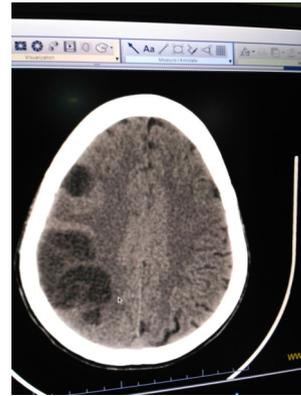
CT image showing infarct Analysis of the data
